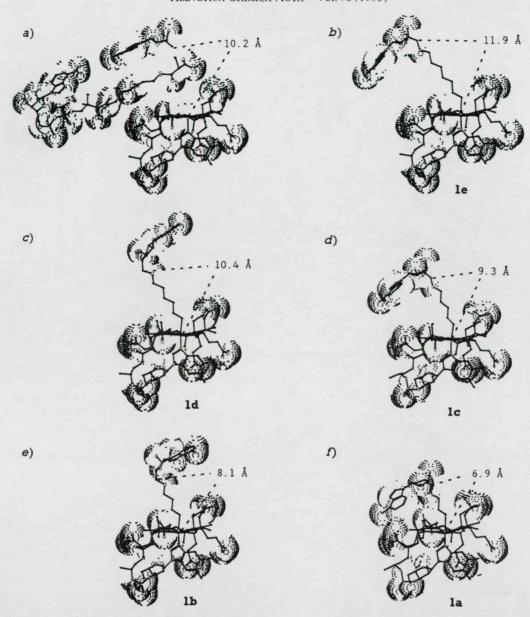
Calculated structures and Co-C(5') distances: a) a hypothetical transition state for the methylmalonyl-CoA mutase and b-f) transition-state analogues 1a-e. Molecular-mechanics calculations were performed on an IRIS-70-G computer (Silicon Graphics) using PCMODEL 4.0 (Serena). X-Ray data of [3-(adenin-9-yl)propyl]cobalamin [17] were applied for building up of the starting structures.
